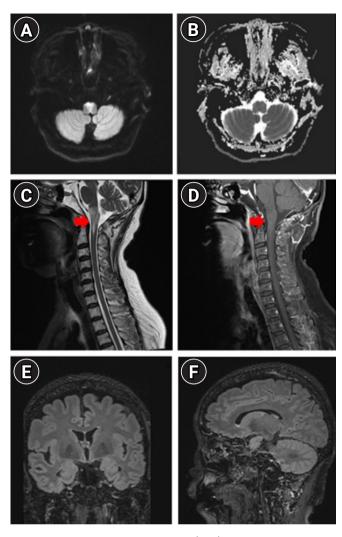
Magnetic resonance imaging (MRI) findings at 2 weeks of hospitalization during management for infarction. Follow-up brain spine MRI revealing further increased signals on the diffusion-weighted imaging sequence on the bilateral anteromedial medulla (A) with a subtle signal change on apparent diffusion coefficient sequence (B) and increased signal intensity on T2 sequence within C1 level of the medullar oblongata and spinal cord with increased enhancement (red arrows; C, D, respectively) during the therapeutic-induced hypertension and anti-thrombotic treatment, including triple anti-platelet agents and tirofiban infusion without evidence of intraventricular and periventricular ependymal lesions (E, F).
